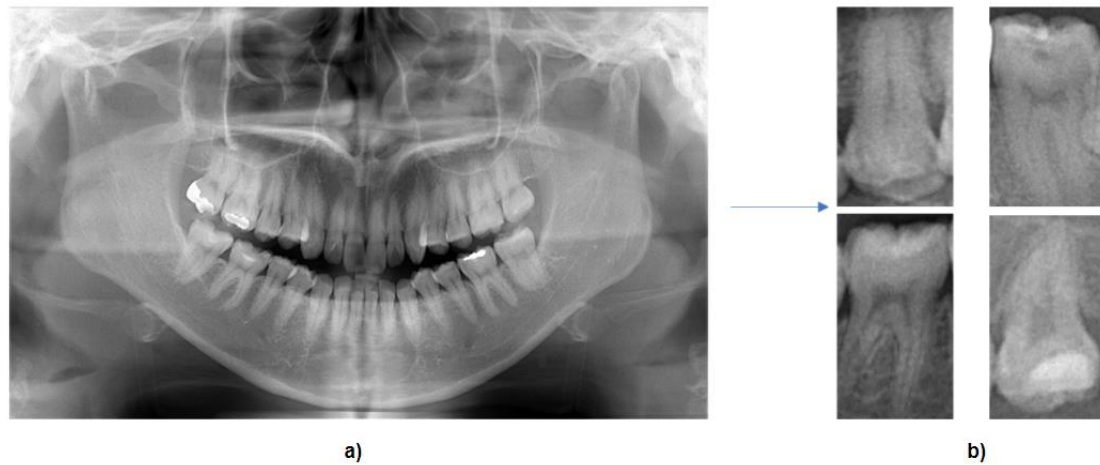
Samples of oral and tooth image. (a) oral panoramic radiograph and (b) segmented tooth radiographs (image credit [58]).
